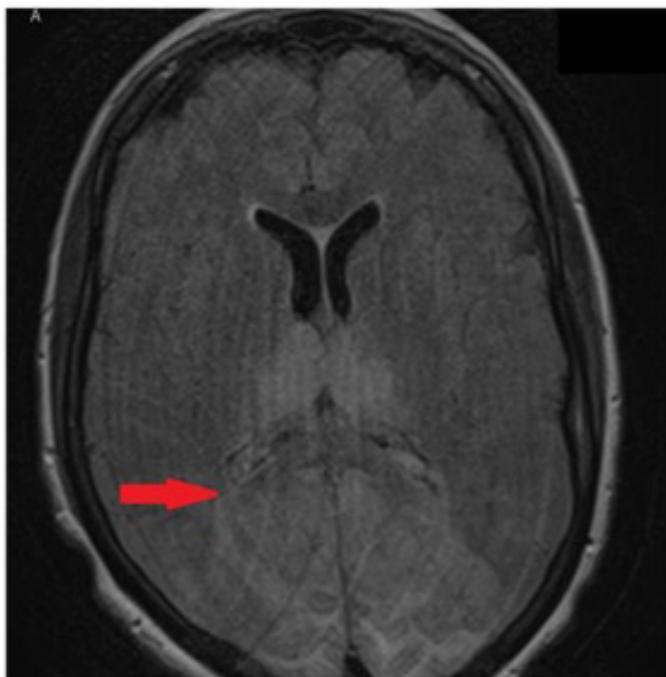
MRI showing increased T2/DWI flair and hyperintense area predominately in occipital lobes, consistent with diagnosis of PRES.
